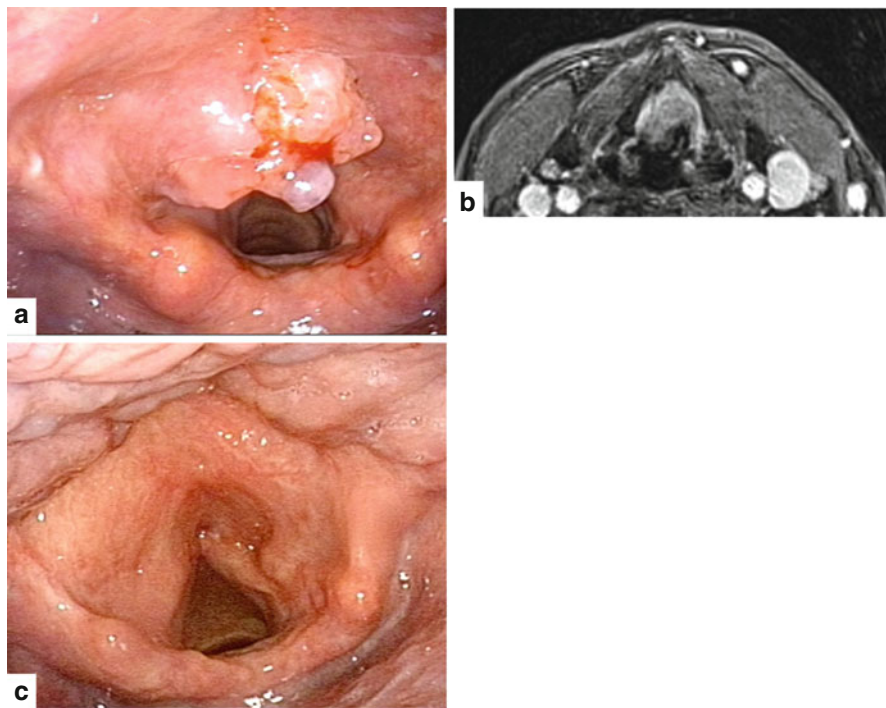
(a) Endoscopic view of an SCC invading the infrahyoid portion of the epiglottis. (b) Preoperative MRI showing partial involvement of the preepiglottic space without infiltration of the thyroid cartilage. (c) Endoscopic view 2 years after TLM
